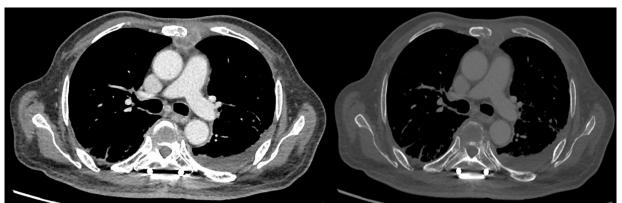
Axial images of the contrast enhanced CT thorax in mediastinal and bone window showing left parasternal enhancing lesion with adjacent bone destruction.
